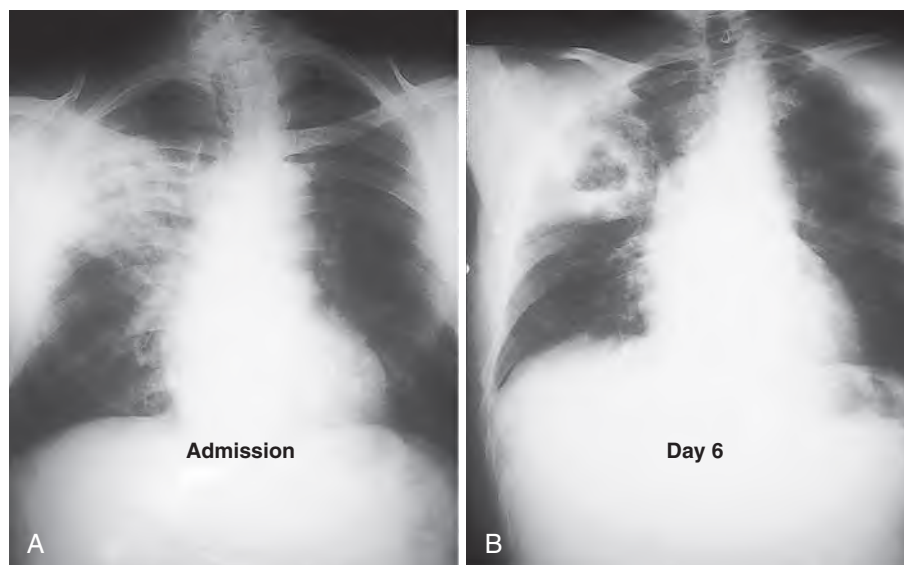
(A) Admission chest radiograph from a 61-year-old man with fever, cough, and putrid sputum of 4 weeks' duration and a 12-pound weight loss. A large infiltrate, without obvious cavitation, is visible in the right lung. (B) A repeat radiograph on day 6 of hospitalization, after the patient began to produce copious sputum, shows a large, thick-walled cavity with an air-fluid level. Because the patient was a heavy smoker and had no aspiration risk and excellent oral hygiene, a bronchoscopy was performed, which showed a partially obstructing carcinoma. (From Lorber B. Bacterial lung abscess. In: Bennett JE, Dolin R, Blaser M, eds. Principles and Practice of Infectious Diseases. 8th ed. Philadelphia: Elsevier; 2014:855–859.)
